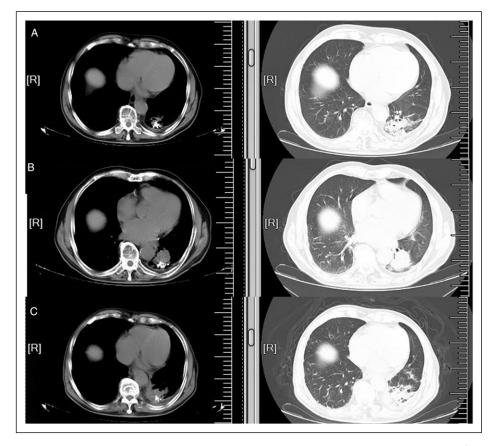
The lesion on chest CT during local radiotherapy. (A) The maximal cross-section of lesion was 45 mm*35 mm on chest CT on August 17th, 2020. (B) The maximal cross-section of lesion was 32 mm*35 mm on October 12th, 2020. (C) The maximal cross-section of lesion was 37 mm*32 mm on January 18th, 2021.
